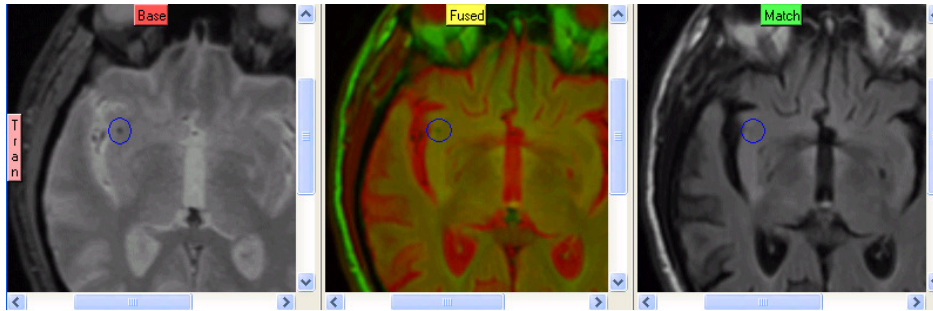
Section of a central axial slice of a subject displaying the registration and colour fusion of T2*W and FLAIR volumes, with a BMB highlighted in the sub-cortical white matter located in the right insula.
